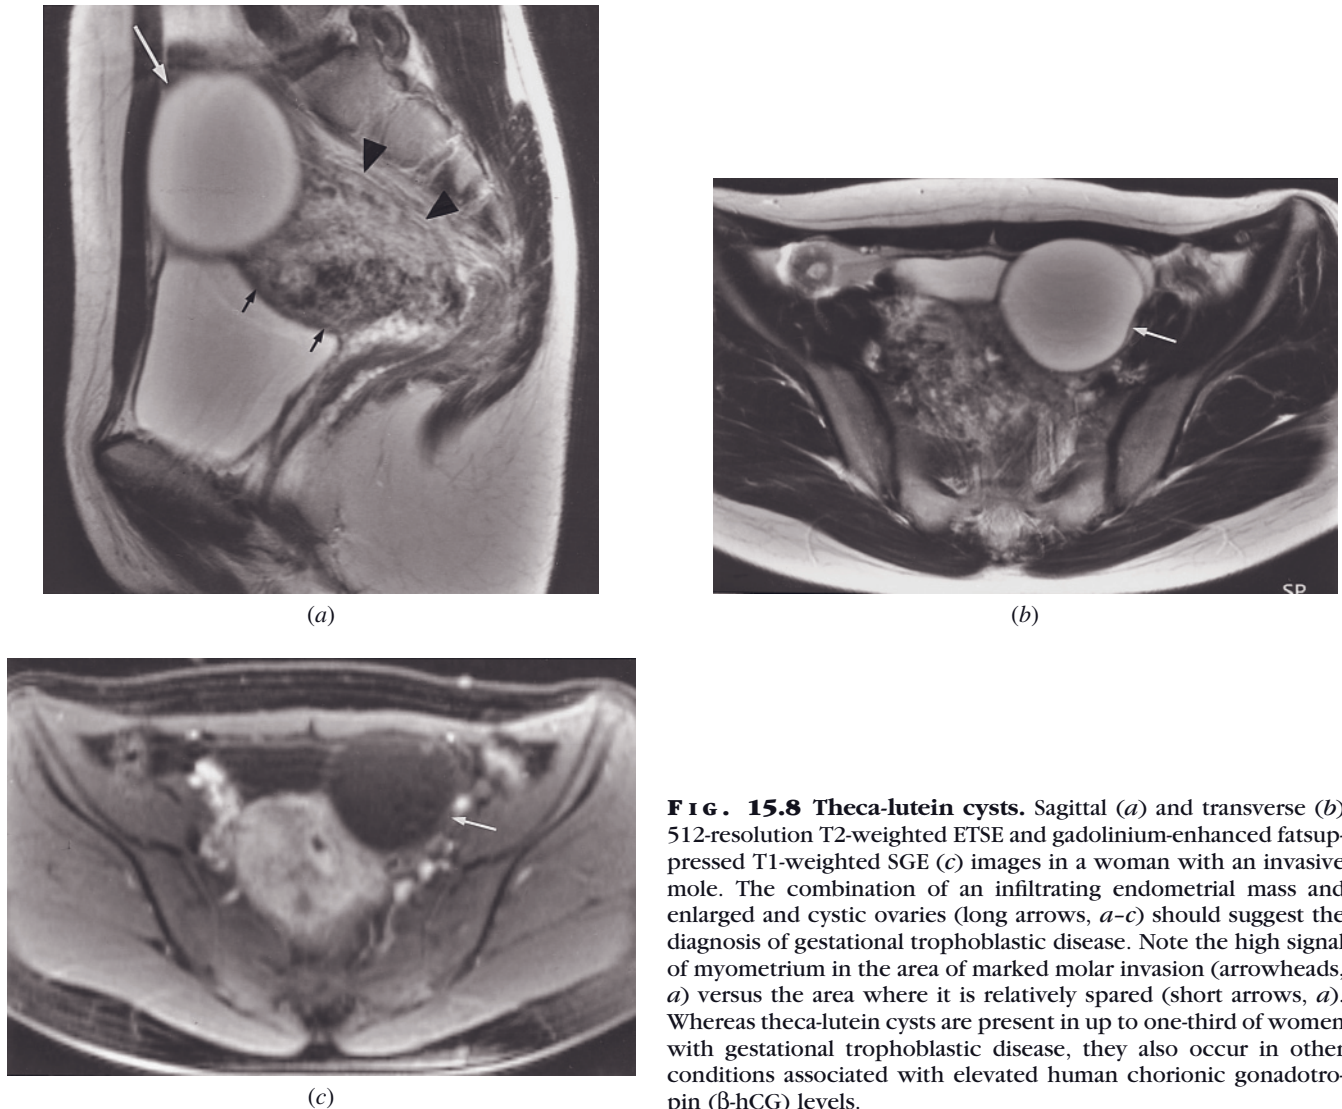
Theca-lutein cysts. Sagittal (a) and transverse (b) 512-resolution T2-weighted ETSE and gadolinium-enhanced fatsuppressed T1-weighted SGE (c) images in a woman with an invasive mole. The combination of an infiltrating endometrial mass and enlarged and cystic ovaries (long arrows, a–c) should suggest the diagnosis of gestational trophoblastic disease. Note the high signal of myometrium in the area of marked molar invasion (arrowheads, a) versus the area where it is relatively spared (short arrows, a). Whereas theca-lutein cysts are present in up to one-third of women with gestational trophoblastic disease, they also occur in other conditions associated with elevated human chorionic gonadotropin (β -hCG) levels.
